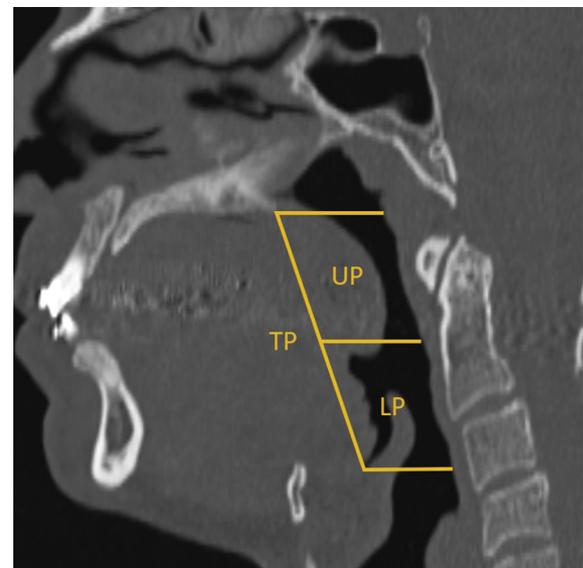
Computed tomographic section of the median sagittal plane showing the divisions of the pharynx used in the present study.
